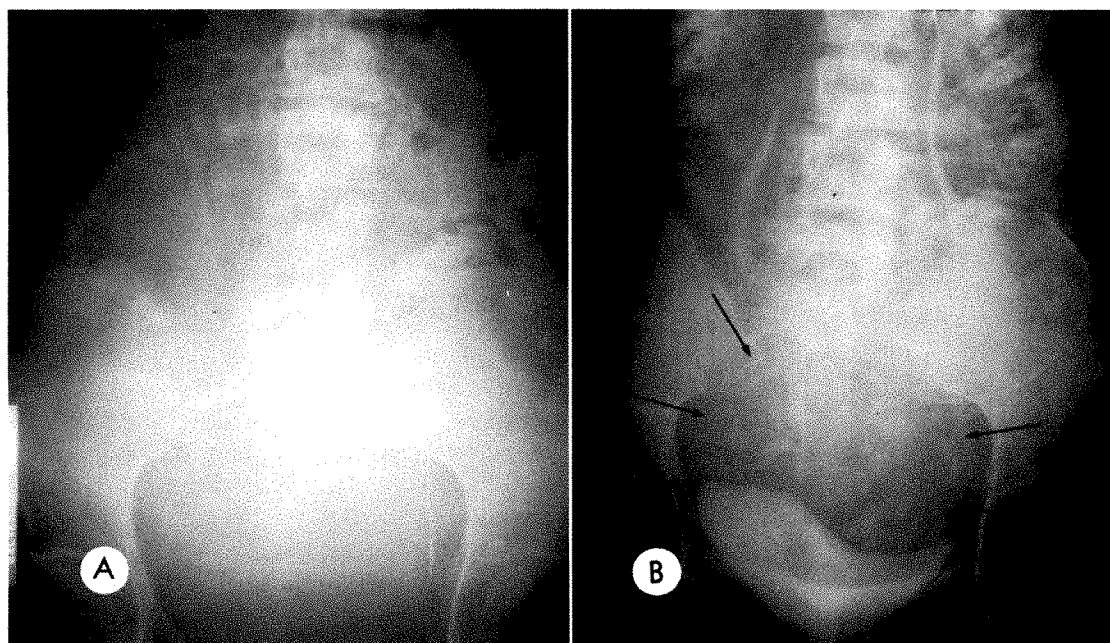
Central placenta previa. (A) Roentgenogram prior to injection of the contrast material shows the fetus in a transverse lie, the head in the left iliac fossa. (B) Roentgenogram made following a second injection of contrast material (the roentgenogram following the first injection was unsatisfactory). The ureters and bladder are opacified from the first contrast injection. The placental sinusoids (arrows) were rendered opaque by the second injection. The placenta is located between the fetal head and the maternal bladder.
